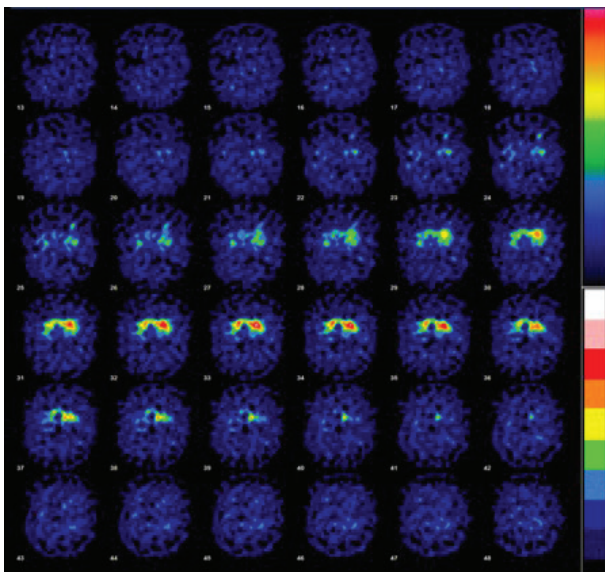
DaT Scan. DaT SPECT with [123I] FP-CIT Shows Absent Uptake in the Bilateral Putamen and Moderately Diminished Uptake in the Right Caudate Head.
